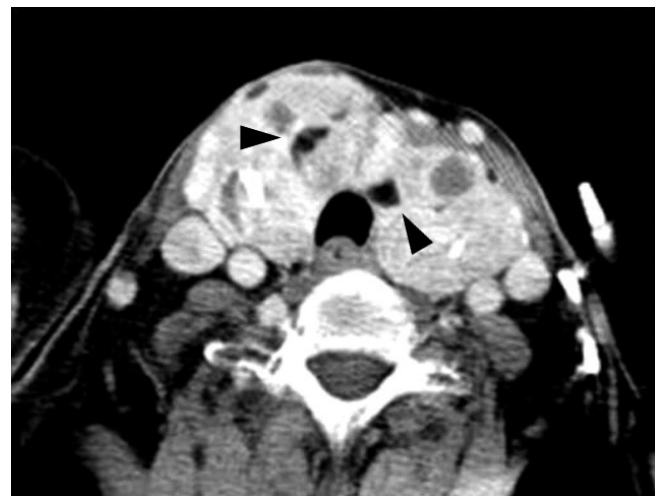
CT scan shows diffuse enlargement of the thyroid gland with macrocalcifications. Note the multiple fat containing nodules (arrowheads), suggesting thyrolipomas.
